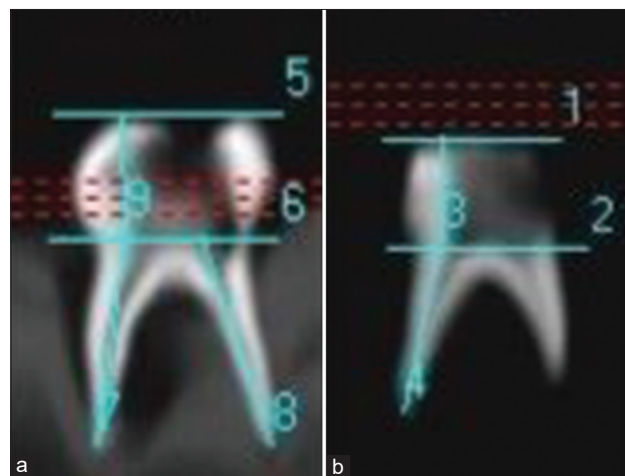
Cone beam computed tomography showing: (a) lower E sample's measurement of crown length and root length. (b) Showing lower D sample's measurement of crown length and root length
